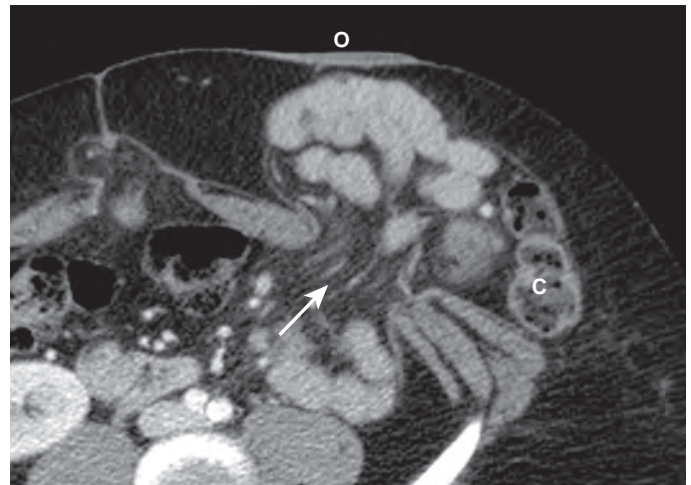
Parastomal hernia. This 51-year-old woman had a history of pelvis leiomyosarcoma requiring distal colonic resection and left lower quadrant colostomy. The CT image shows a large anterior abdominal wall defect with herniation of multiple small bowel loops and mesentery (arrow). The colon (c) proximal to the ostomy (o) is displaced to the side. This diagnosis requires careful review of several scan slices because the herniated loops and stoma are often in different axial scan planes.
